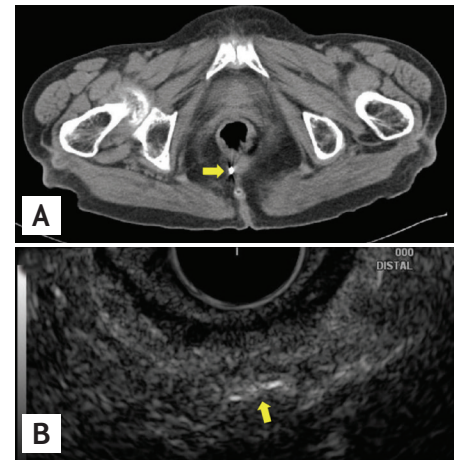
(A) Computed tomography revealed a metallic-density foreign body (arrow) in the distal posterior wall of the rectum. (B) Endoscopic ultrasonography revealed a 6-mm hyperechoic linear lesion (arrow) at the same lesion, suggesting retained acupuncture needle.
